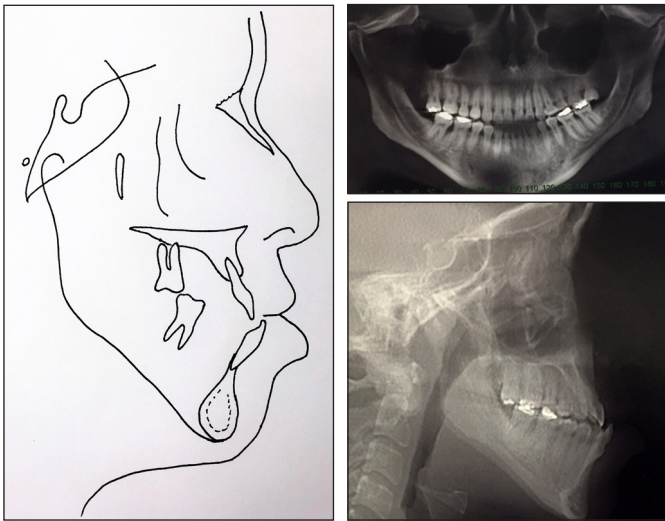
Pre-treatment lateral cephalometric and panoramic radiographs
